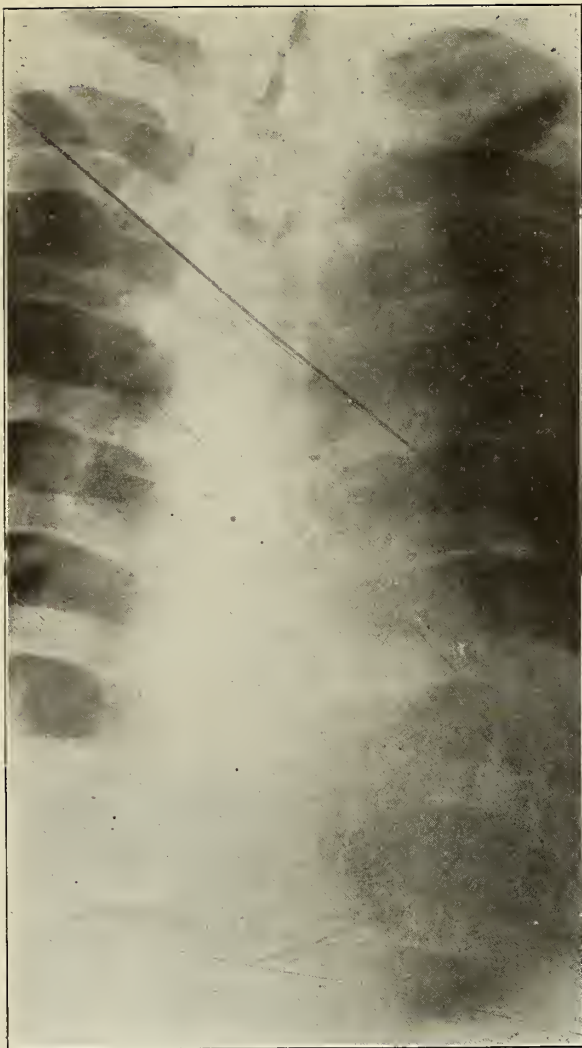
(Case 316979) Roentgenogram of spina bifida occulta of the upper thoracic area.
